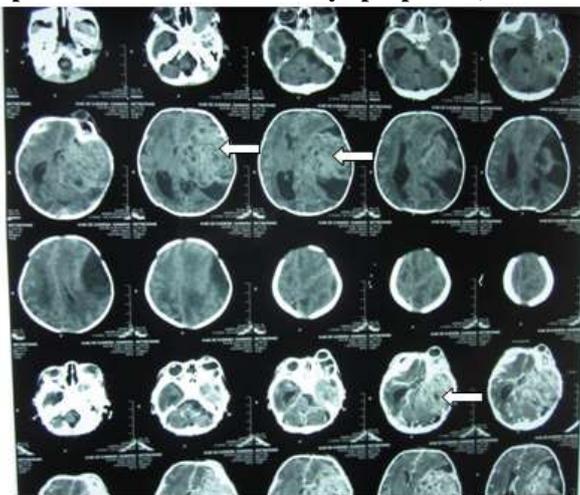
CT scan displaying a huge brain tumor (see arrows)
